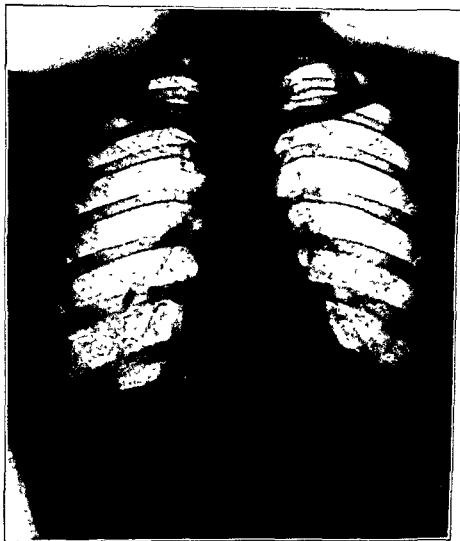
An x-ray taken ten years following the x-ray in Fig. 59. There has been no change in physical findings. The patient, except for a short rest, has been carrying on these past ten years.
